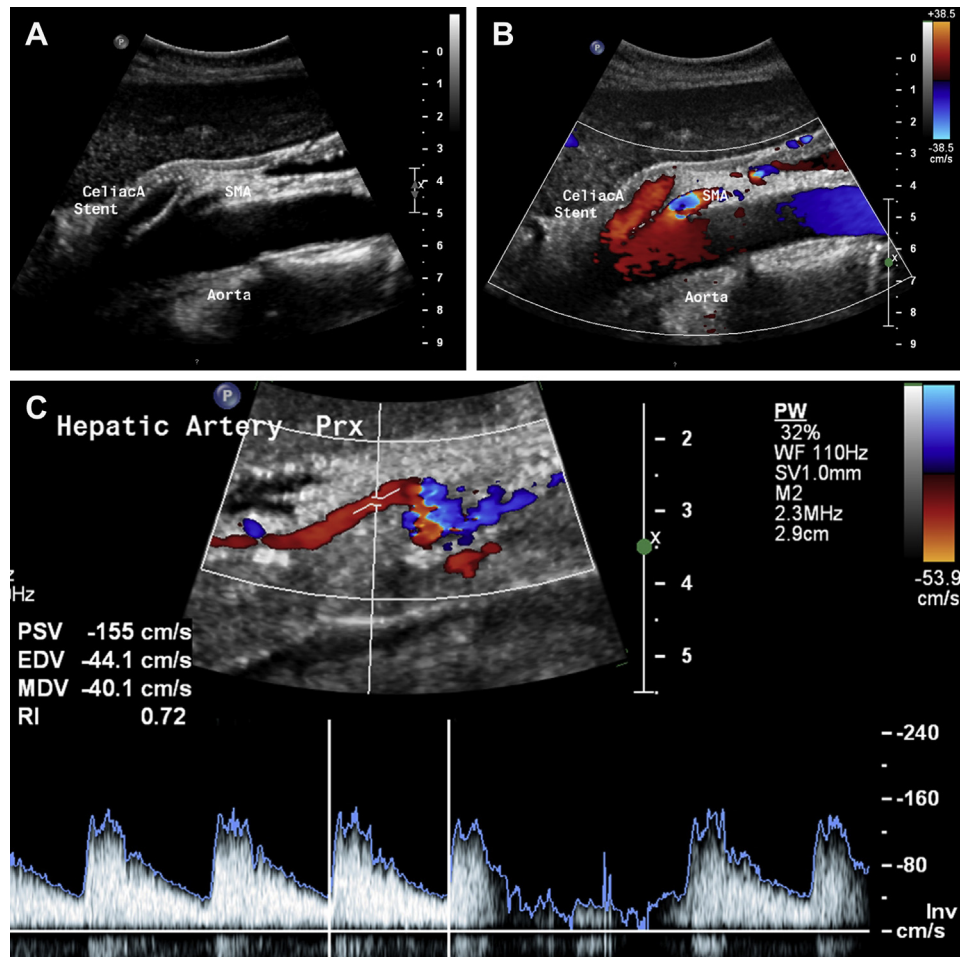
A follow-up duplex ultrasound image at 3 months demonstrates (A) celiac-hepatic artery stent graft, (B) continued aneurysm exclusion with no evidence of endoleak, (C) patent hepatic and gastroduodenal arteries. The ultrasound cursor is in the common hepatic artery.
